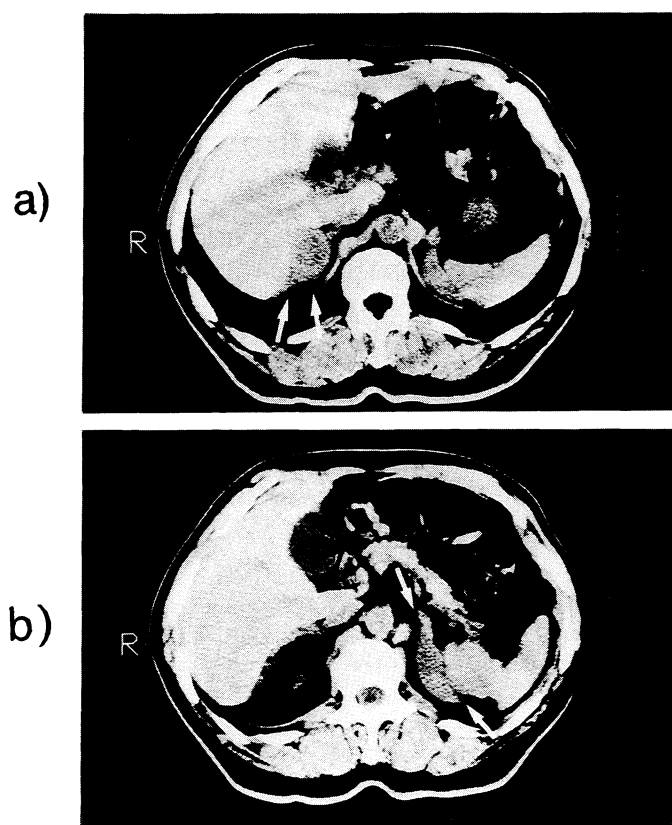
CT scans of (a) the right adrenal gland and (b) the left adrenal gland. The arrows indicate the adrenal masses.
